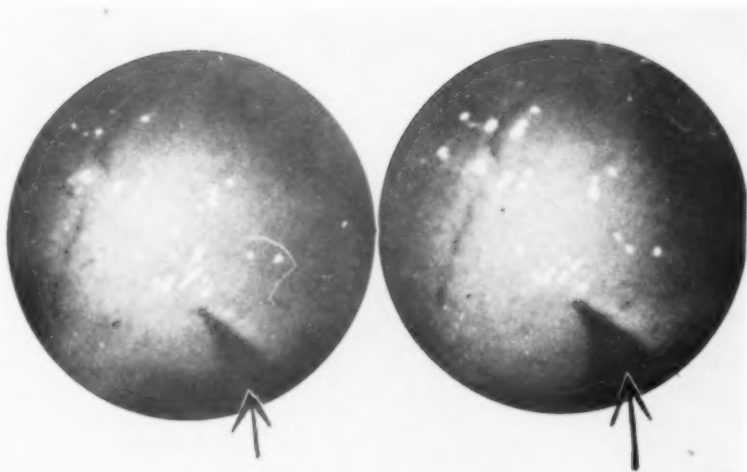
Only spasm shown in case where X-ray shows a prepyloric ulcer.
